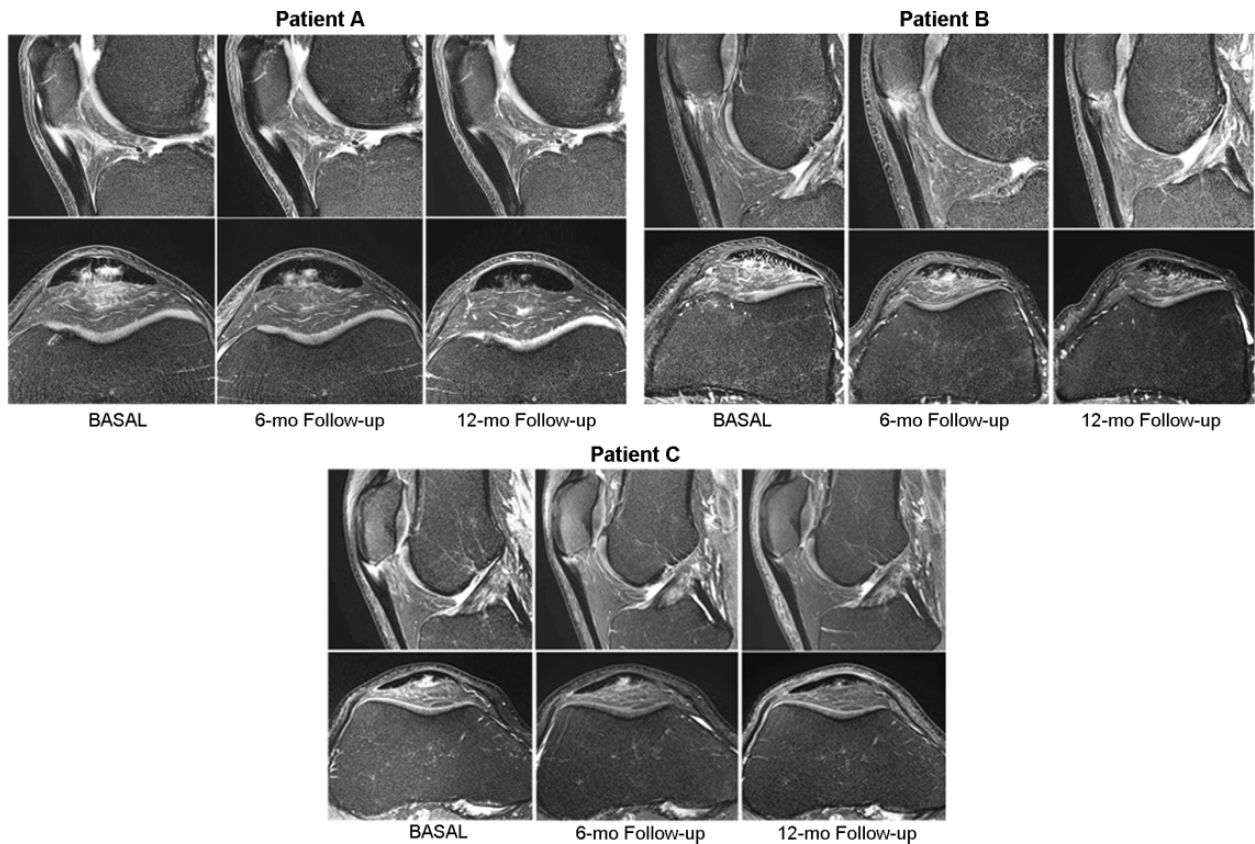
Sagittal (top row) and axial (bottom row) T2-weighted fat-saturated magnetic resonance imaging sequences of 3 patients who were initially treated with leukocyte-poor platelet-rich plasma (Lp-PRP) and then with bone marrow-derived mesenchymal stem cells (BM-MSCs). Shown are images from baseline, the 6-month follow-up (after Lp-PRP), and the 12-month follow-up (after BM-MSCs).
